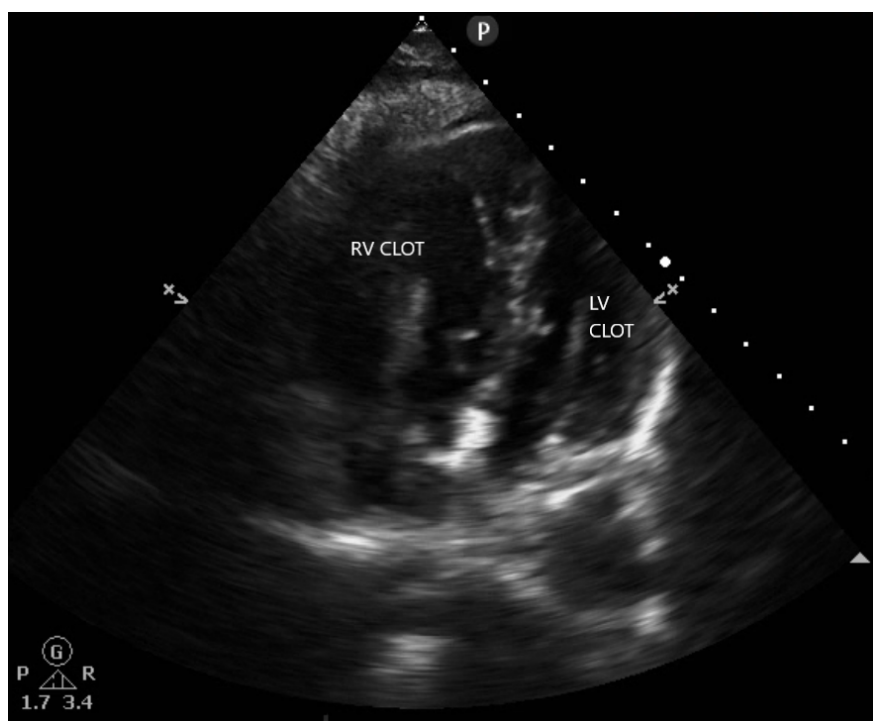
Apical 4 chamber view showing thrombus in transit across interatrial septum, protruding into right and left ventricular cavity
